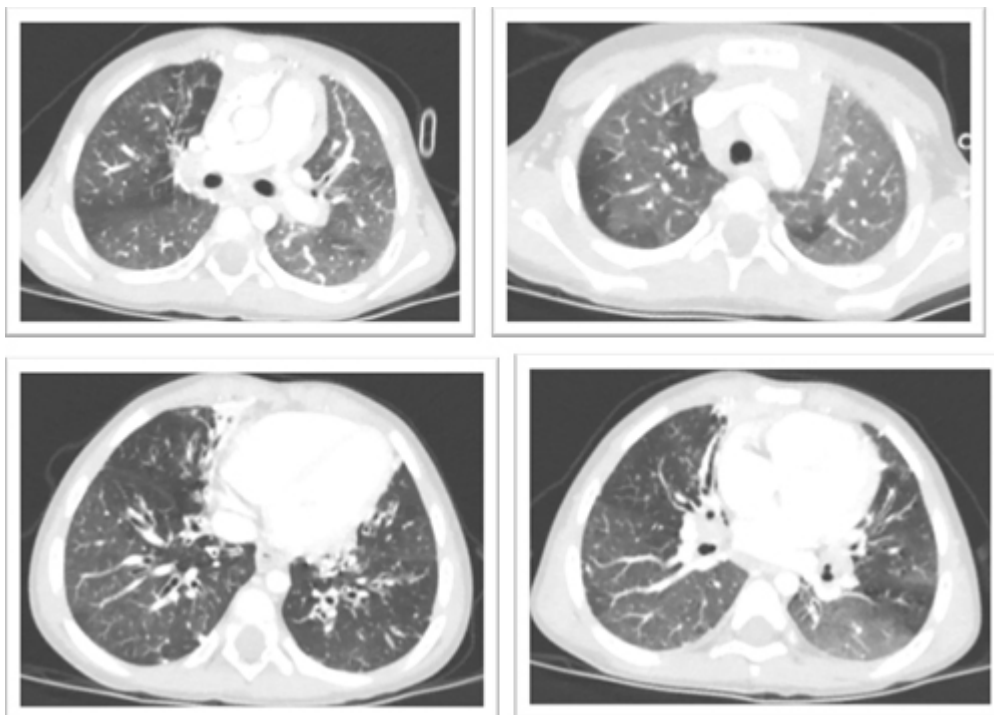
CT at age 2 years. ↩
